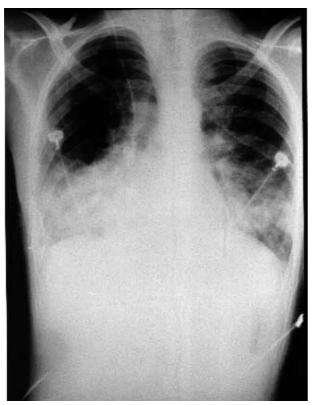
The chest radiograph of patient No. 1 (following initiation of treatment with steroids) demonstrating resolution of the changes in the left lung with a new " migratory" infiltrate in the right lower zone.
